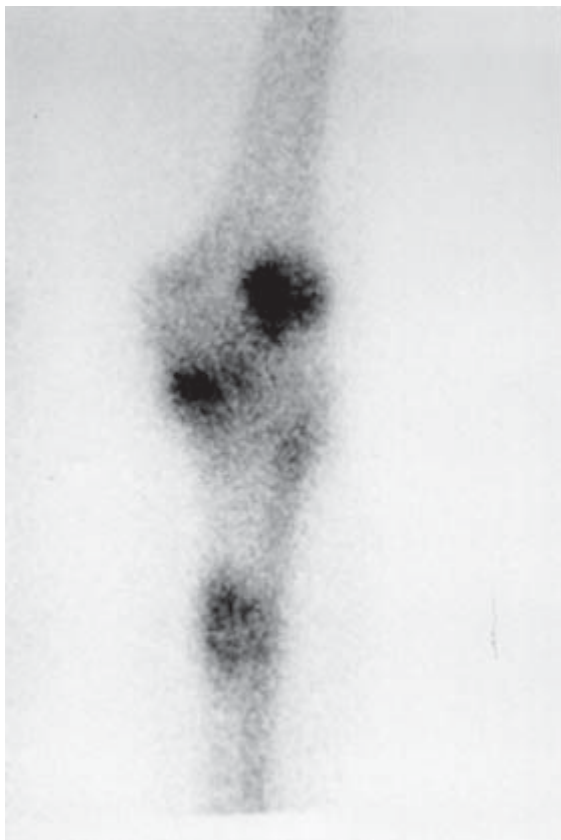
In the scintigraphic scanning, tibial lesion and distal femoral lesions are demonstrating significantly high osteoblastic activity.
